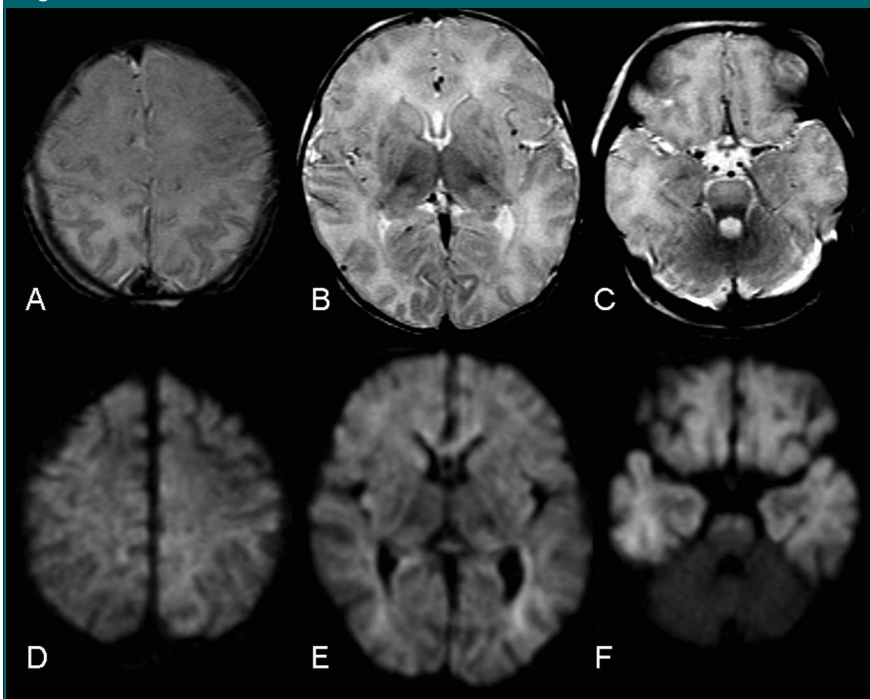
MR images at day 6 in an infant with a diffuse pattern of cerebral damage, who died in the neonatal period. *A–C*, T2-weighted images with abnormal cortical rim throughout the entire cortex, an abnormal high signal intensity in the basal ganglia, and high signal intensity in the frontal periventricular areas. *D–F*, DW images ($b = 1000 \text{ sec/mm}^2$) show a global high signal intensity in the cortex and basal ganglia. The cerebellum has a normal low signal intensity (also described as the white cerebrum [9]) and the cerebral peduncles have a high signal intensity.
